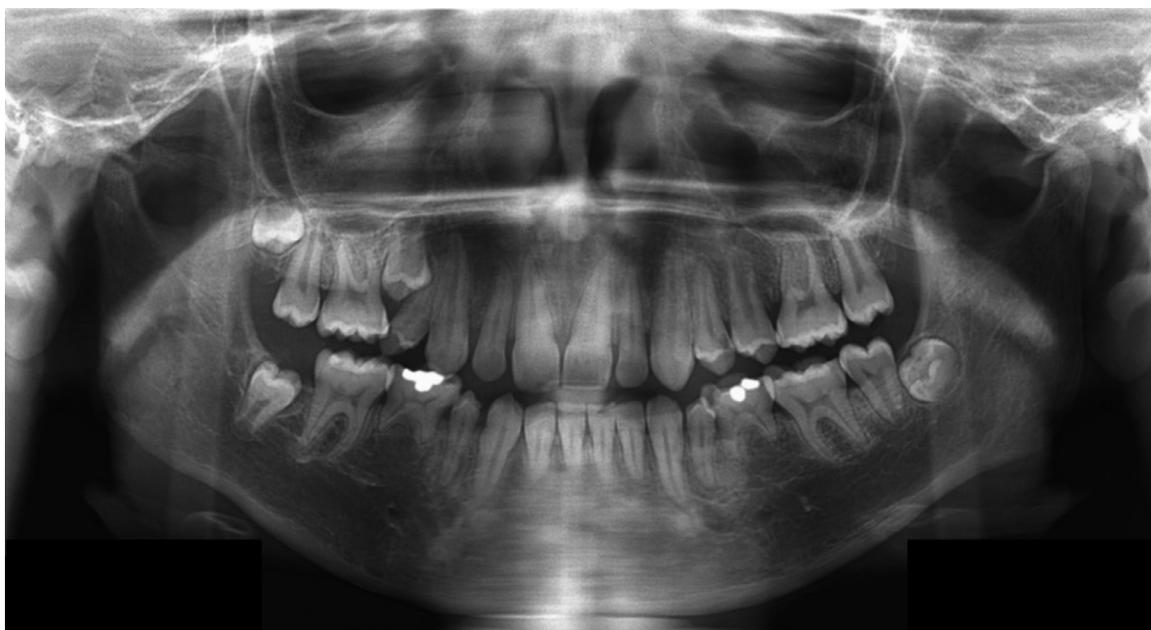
Panoramic radiograph of a 15-year-old individual who had been diagnosed with rhabdomyosarcoma at age 28 months and submitted to chemotherapy for 15 months, revealing hypodontia of the second lower premolars, and microdontia of the first lower premolars.
